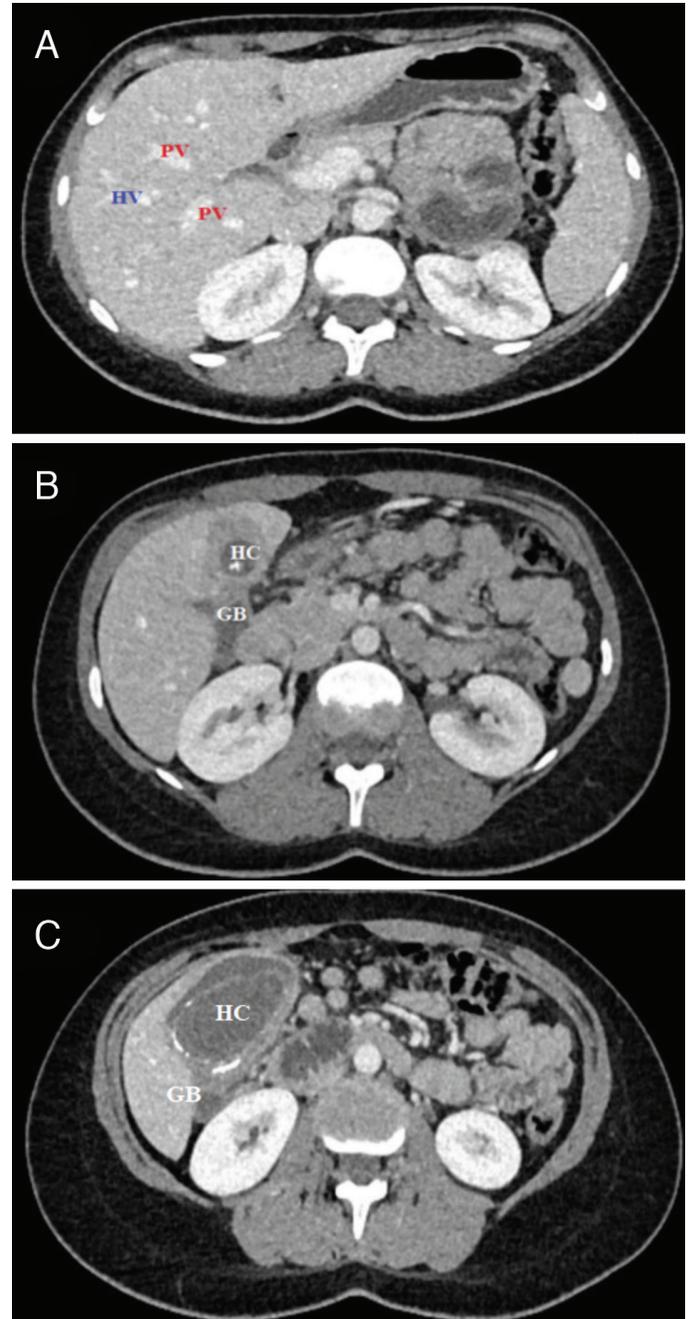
Computed tomography images of liver hydatid cyst. A. Branches of portal vein and hepatic vein, irrelevant to hepatic hydatid cyst. B and C. A single thick-walled cystic lesion with detached laminar membranes placed anteriorly in segment 5-6 and attached to the gallbladder
